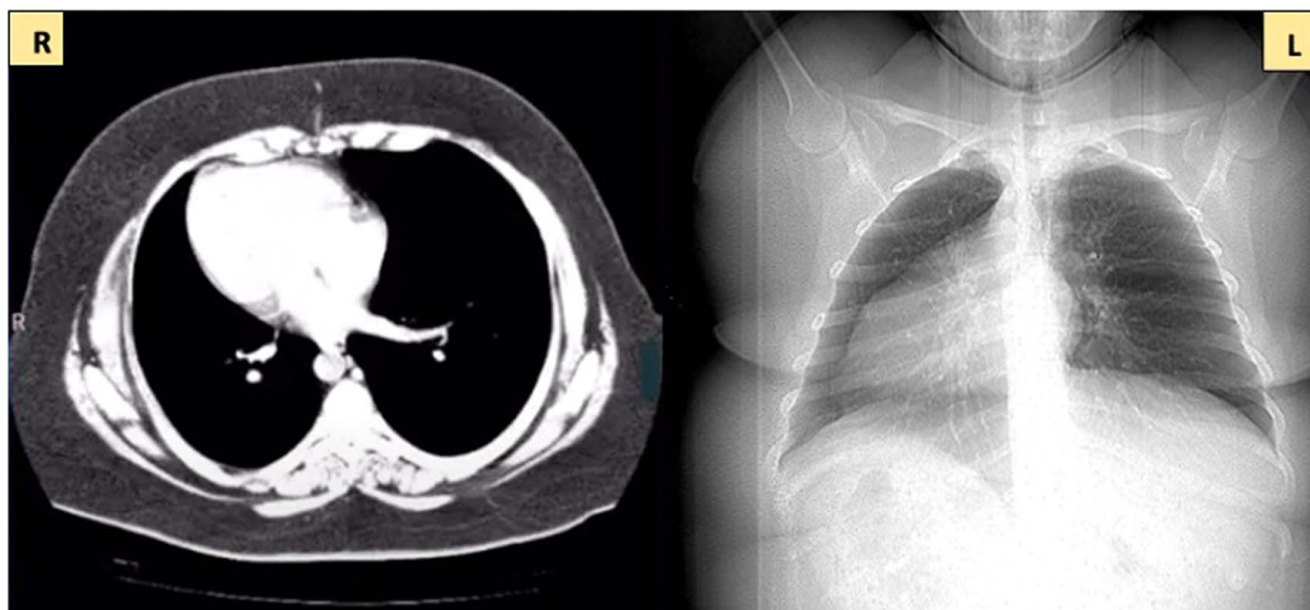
Situs inversus present in computed tomography and chest radiograph.
